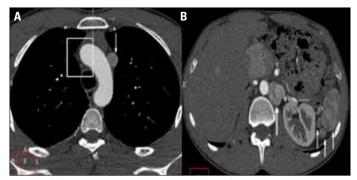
(A). Left-sided superior vena cava (arrow), the superior vena cava is absent on the right side (rectangle), (B). Multi dedector CT- Polysplenia (arrows) and hemiazygos continuation of the inferior vena cava (double arrow)
